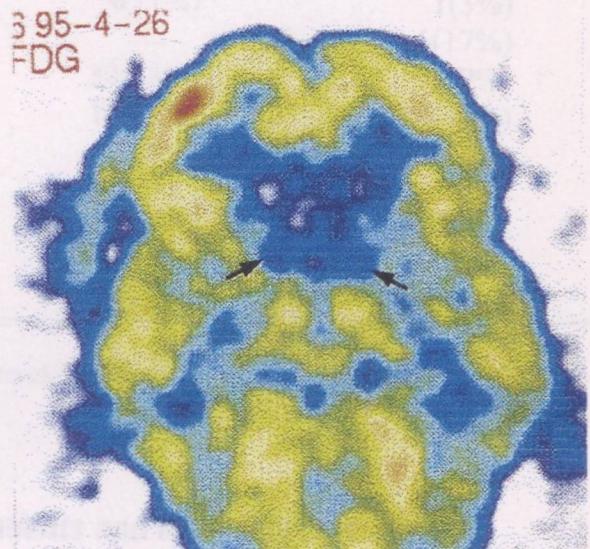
[(18)F]FDG-PET detects reduced glucose metabolism in the basal ganglia of a HD patient
